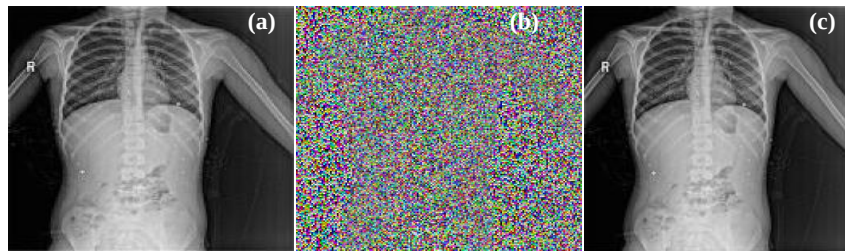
Medical image X-ray encryption using the chaotic method when $X= 0.1; U = 4$: (a) Original X-ray Image, (b) Encrypted X-ray Image, and (c) Decrypted X-ray Image
